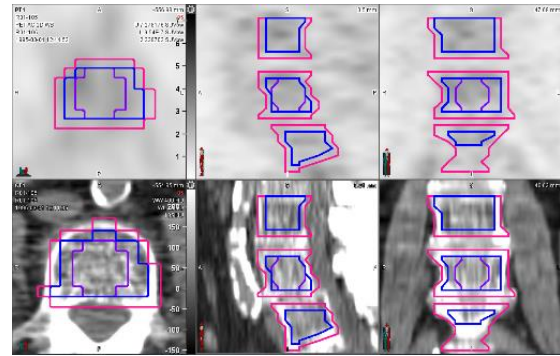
The original segmentation (pink), 5mm erosion (blue), and the largest inscribed sphere (violet). The top row is the PET image, and the second row is the CT images.
